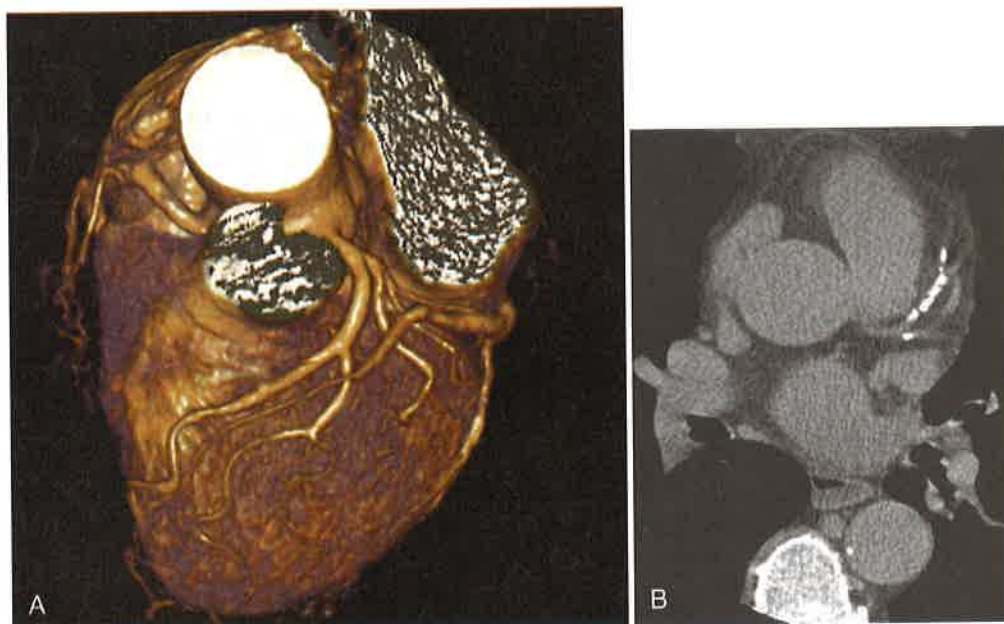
(A) Computed tomography angiography (CTA) showing coronary arteries. High radiation is a drawback to the use of CTA. (B) Electron beam computed tomography showing significant calcification (*white areas*) in the coronary arteries, indicating advanced coronary artery disease. (A, Courtesy Massachusetts General Hospital, Boston; B, from Crawford MH, DiMarco JP, Paulus WJ: *Cardiology*, 2nd ed., St. Louis, Mosby, 2004, p. 224.)
